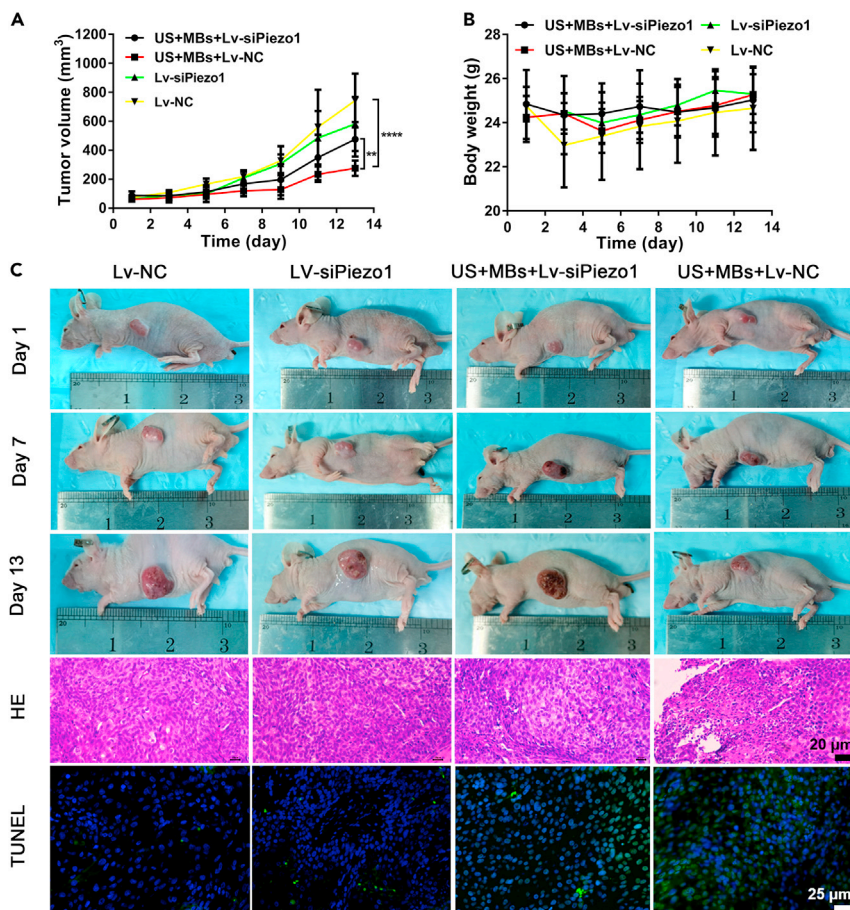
Knockdown of Piezo1 reduces the therapeutic effect of ultrasound with microbubbles *in vivo*
